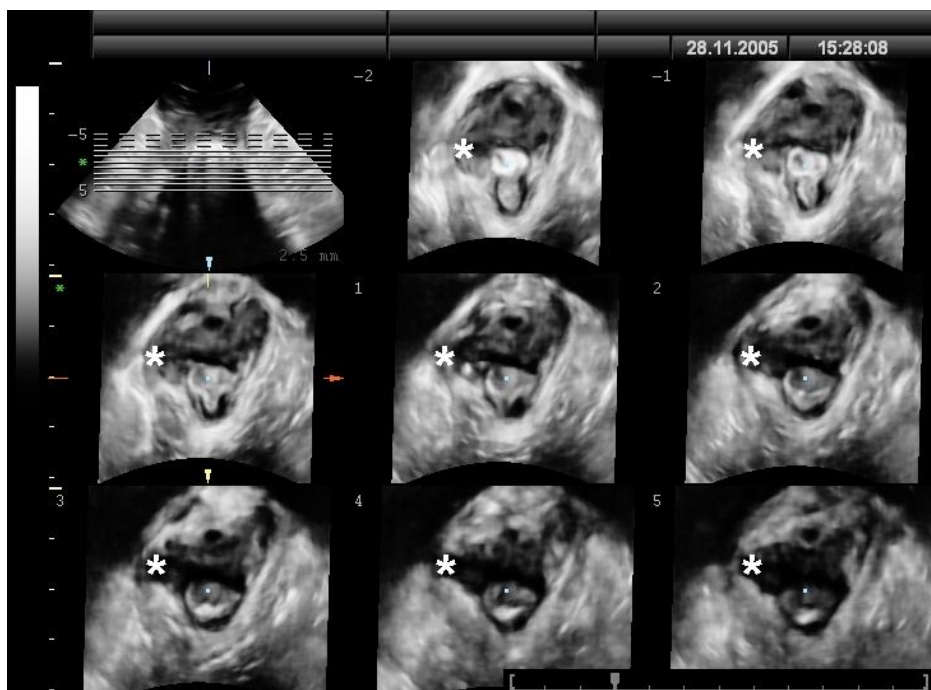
Unilateral levator avulsion injury in a patient with three compartment prolapse after previous hysterectomy. The asterisk denotes a right-sided defect as demonstrated on tomographic pelvic floor ultrasound (visible on the left hand side of individual slices).
